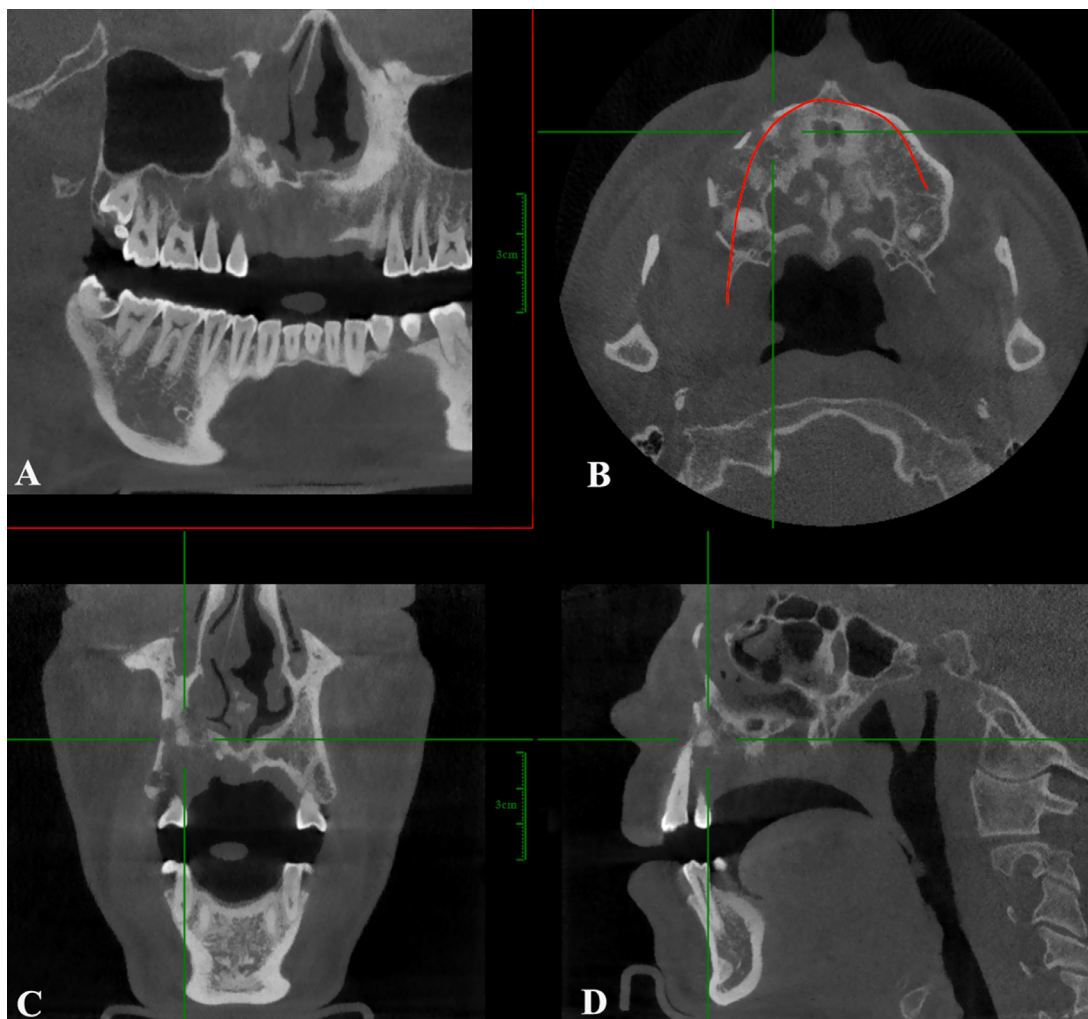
Cone beam computed tomography imaging identified an irregular, osteolytic lesion in the right upper alveolar bone. (A, B) A virtual panoramic radiograph generating from the plane indicated as a red curve (B) showed the lesion involving the right maxillary sinus and hard palate. (C, D) The lesion had no obvious boundary and there was a moth-eaten resorption of the surrounding bones.
